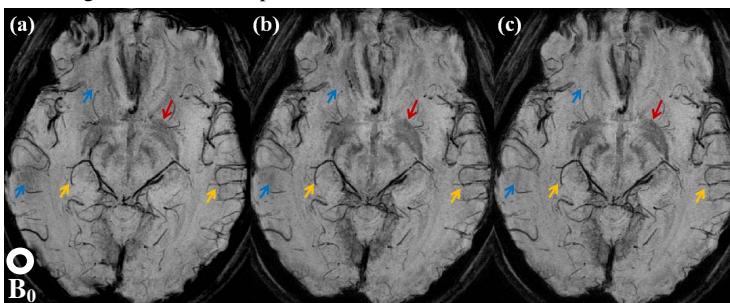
Axial images in closed-type MRI by (a) SWI, (b) tSWI, and (c) SDWI.
